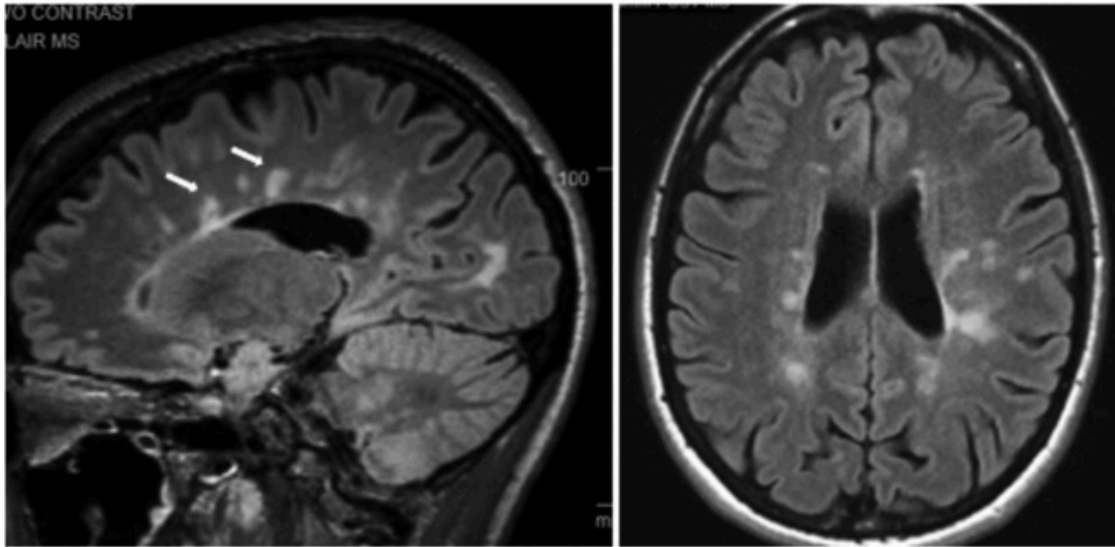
MRI scan of a MS patient showing typical lesions from Hemond et al 2018. The lefts picture shows a sagittal image, the arrows point to characteristic periventricular lesions forming so called Dawson's fingers. On the right side there is an axial scan of the same patient. (Hemond & Bakshi, 2018) (© to Cold Spring Harbor Laboratory Press)
